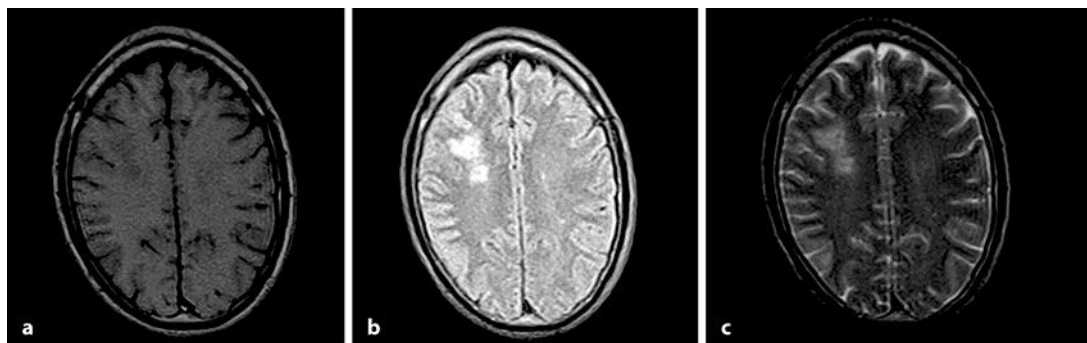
T1 (a), FLAIR (b), and T2 (c) magnetic resonance imaging confirmed the ischemic area in the right frontal and parietal lobe.
